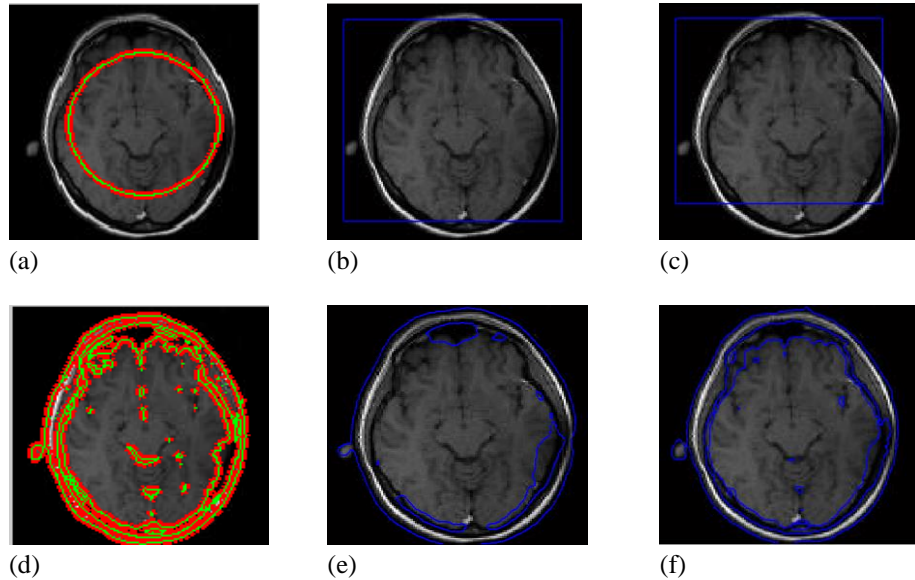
Brain MRI image segmentation. The final results using the C–V, SGLACM, and proposed methods are shown in the first, second, and third columns when $\alpha=0.077$ and $\sigma = 1.0$, respectively. The first row shows the initial contour and will be applied throughout the experiments.
